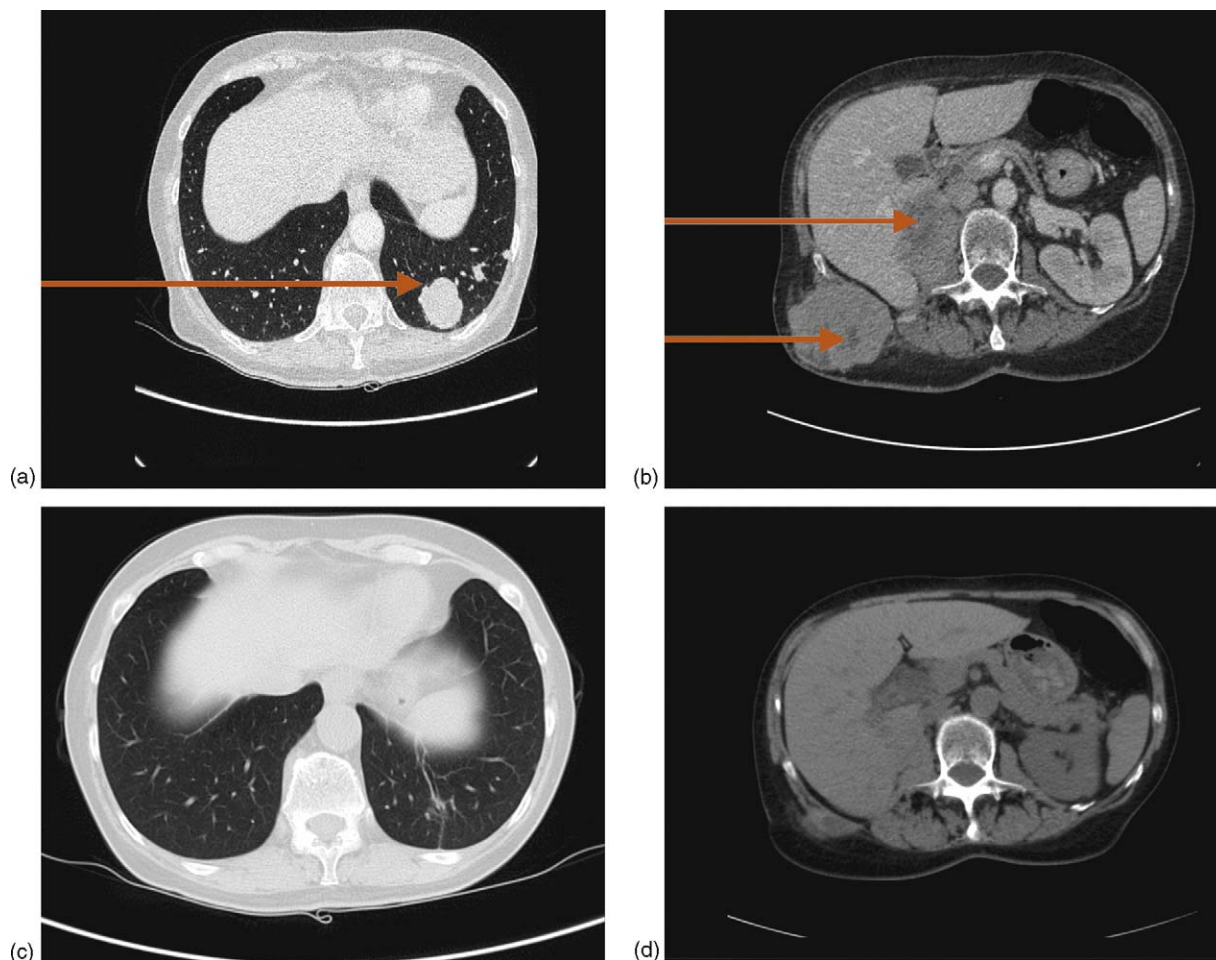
(a) Lung computed tomography (CT) scan and (b) abdominal CT scan of a patient with metastatic renal cell carcinoma prior to treatment with everolimus; (c) lung CT scan and (d) abdominal CT scan of patient 16 mo after initiation of everolimus treatment. Arrows indicate metastases.
